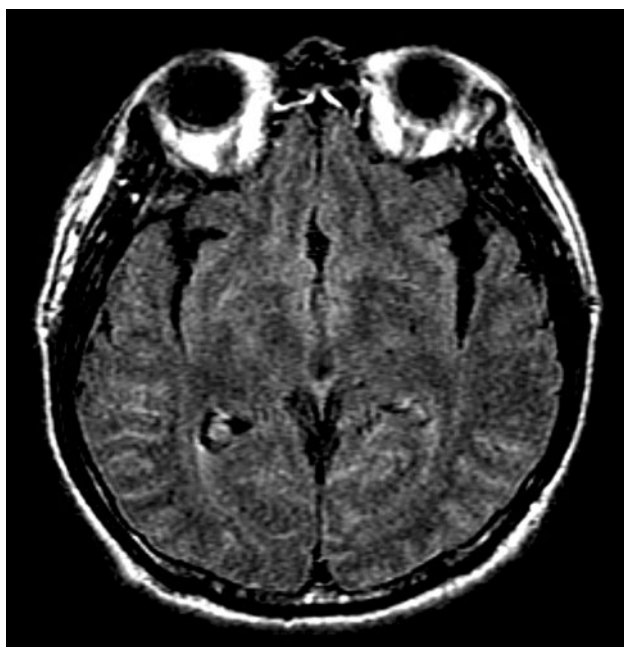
Brain magnetic resonance imaging (fast, low-angle inversion recovery sequences). Postcontrast view showing enhanced interhemispheric and occipital meninges
